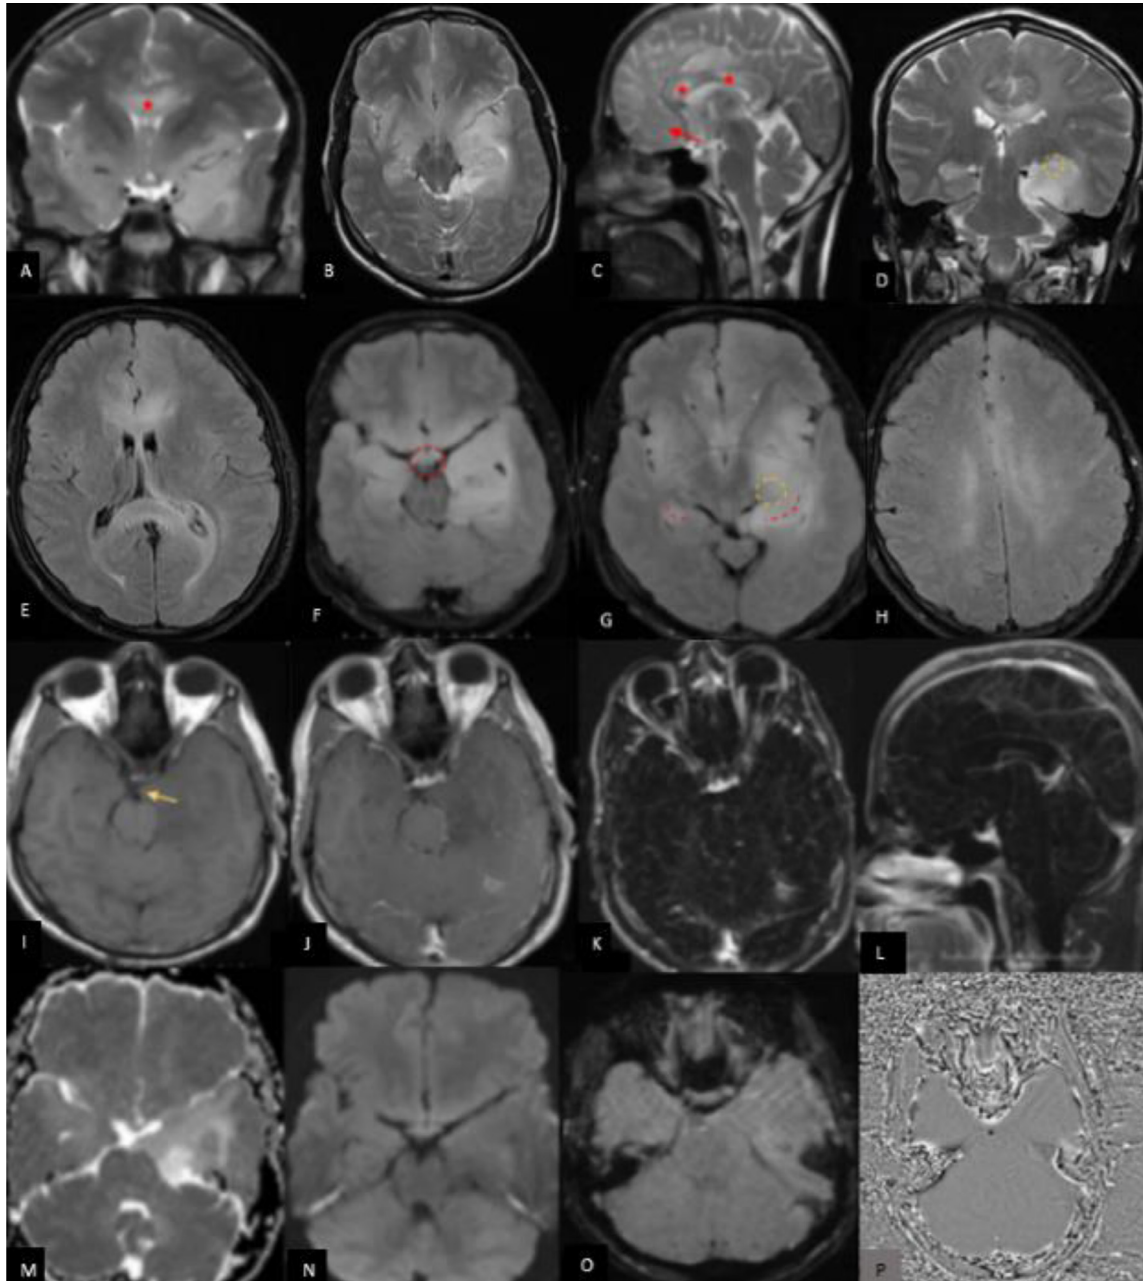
Brain MRI. Coronal (A and D), axial (B), and sagittal (C) planes of the brain MRI (T2weighted sequence) showed hyper-signal intensity in bilateral temporal lobes (A, B and D), genu and body of corpus callosum (red stars in A and C) as well as in the optic chiasm (red arrow in C). Hyper-signal regions are mildly expanded (for example, note the gyral thickening of the left medial temporal cortex in B and enlargement of the body of corpus callosum in A). Hyper signal intensity is noted in the anatomic location of the left lateral geniculate body in the posterior coronal plane (yellow circle in D). Selected slices of the FLAIR-axial plane of the brain MRI show Hyper-signal intensity in genu and splenium of the corpus callosum as well as bilateral posterior periventricular white matter (E), bilateral temporal lobes (F and G), the optic chiasm (red circle in F), bilateral insular cortexes, left basal ganglia and left thalamus (G) and also bilateral centrum semiovale (H). Hyper signal intensity is noted in the anatomic location of the left lateral geniculate body (yellow circle in G) and proximal portion of the bilateral optic radiations (dashed red lines in G which is more prominent on the left side). Hyper-signal regions on the T2-weighted and FLAIR exams are mildly hypo-signal on the axial T1-weighted sequence (I). Mild left uncus herniation is seen (yellow arrow in I). Axial T1-weighted sequence with contrast (J), as well as axial and sagittal subtraction images (K and L respectively), show no abnormal leptomeningeal or parenchymal contrast enhancement in the brain. (M and N) There is no obvious diffusion restriction on the DWI/ADC. No Blooming foci are seen in the SWI (O). No abnormal hypo or hyper signal intensity is noted in the filtered phase image (P). So there are no hemorrhagic or calcification foci in the mentioned areas.
